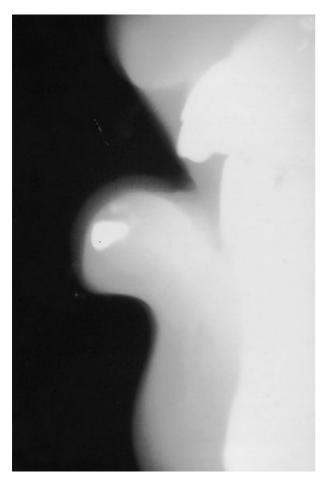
The preoperative lateral X-ray of the soft tissues showed a radiopaque image included in the lower lip tissues.
